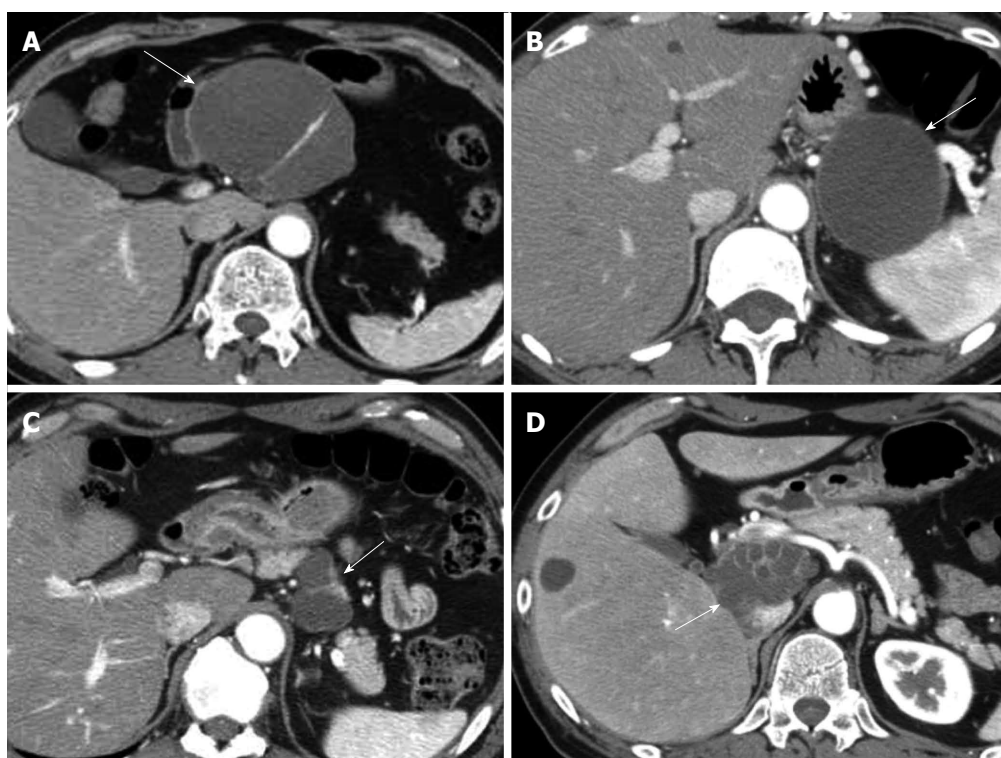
Computed tomography findings. All lesions were well-defined and were exophytic off the pancreatic parenchyma. The wall and septum of the cysts were enhanced. A: Findings of Patient #1, the lesion was localized in the body of the pancreas and had a multilocular cystic appearance (arrow); B: Findings of Patient #2, the lesion was localized in the tail of the pancreas and had a unilocular cystic appearance (arrow); C: Findings of Patient #3, the lesion was localized in the body of the pancreas and had a multilocular cystic appearance (arrow); D: Findings of Patient #4, the lesion was localized in the head of the pancreas and had a multilocular cystic appearance (arrow).
